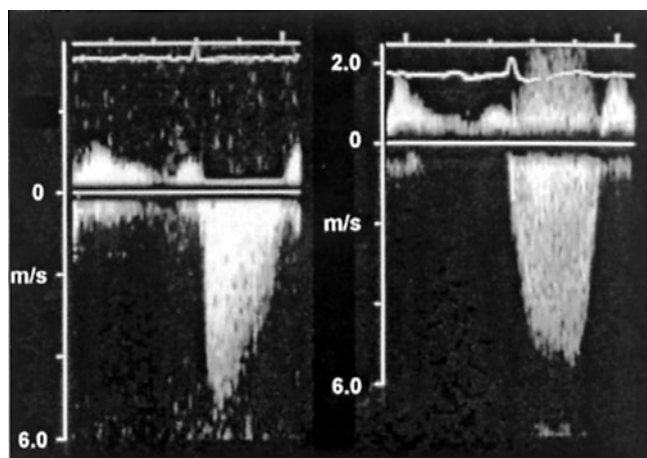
Continuous-wave Doppler of mitral regurgitant (MR) jets. (Left) The jet is holosystolic, but the peak velocity is reached during the first half of systole, suggesting the existence of a large *v* wave on the left atrial pressure, which leads to rapid equalization of pressure between ventricle and atrium. This type of jet is seen often in acute MR. (Right) The jet is also holosystolic, but the peak velocity is reached in middle to late systole without late effacement of velocity. This type of jet is seen often in patients with chronic MR without a large *v* wave.
